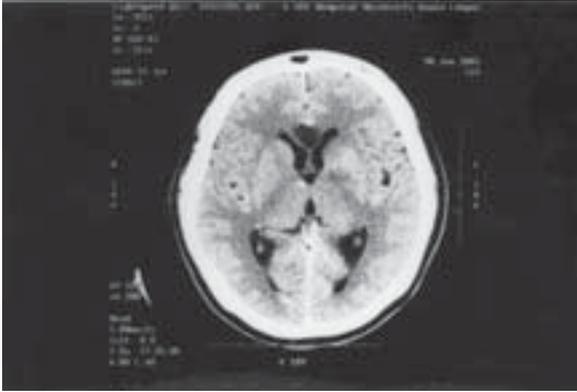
Contrast-enhanced CT at the level of the third ventricle shows non-enhancing hypodense area in the region of the corpus callosum. Subtle hypodense area seen within the genu of the left internal capsule.
